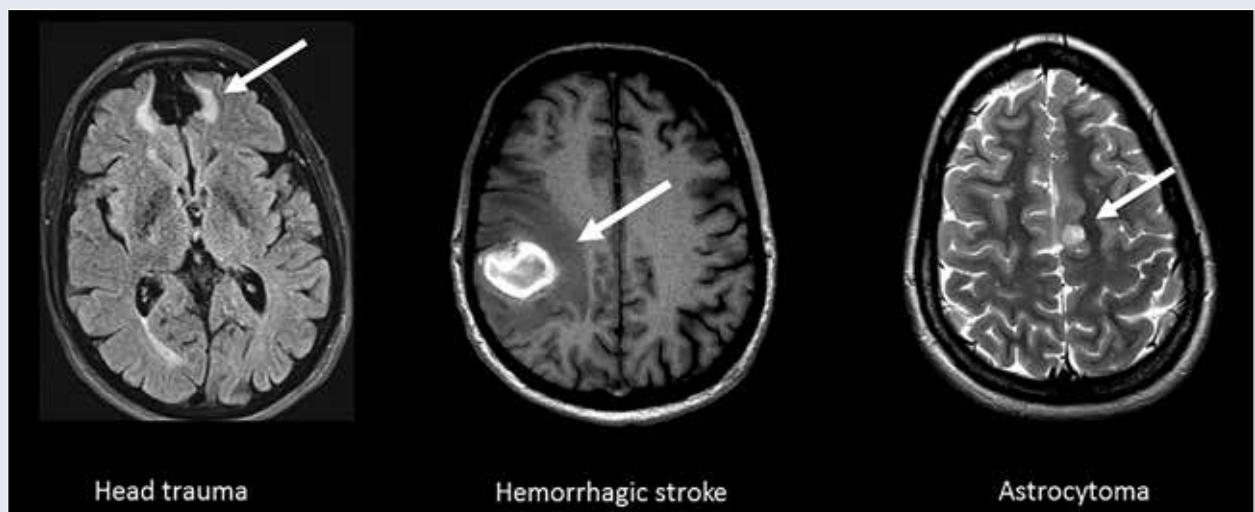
Typical imaging findings in patients with first seizure. Left: FLAIR image with bilateral fronto-polar/fronto-mesial chronic lesions after head trauma. Middle: Right cortico-subcortical subacute haemorrhage on T1-weighted image. Right: T2-weighted image showing a T2-hyperintense tumor adjacent to cortical tissue of the left SMA. Cortical involvement of the lesion indicates epileptogenic potential.
